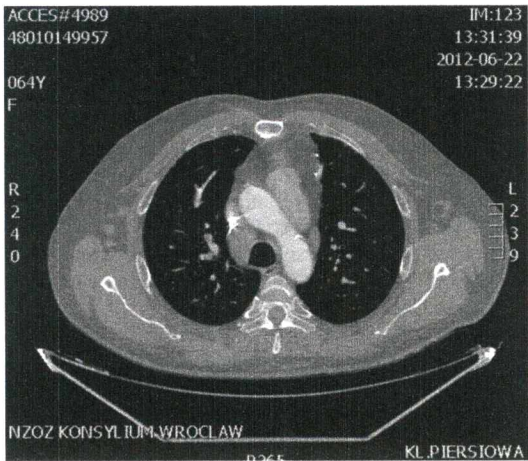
CT scan showing an enlarged right lower paratracheal lymph node (station 4R)
